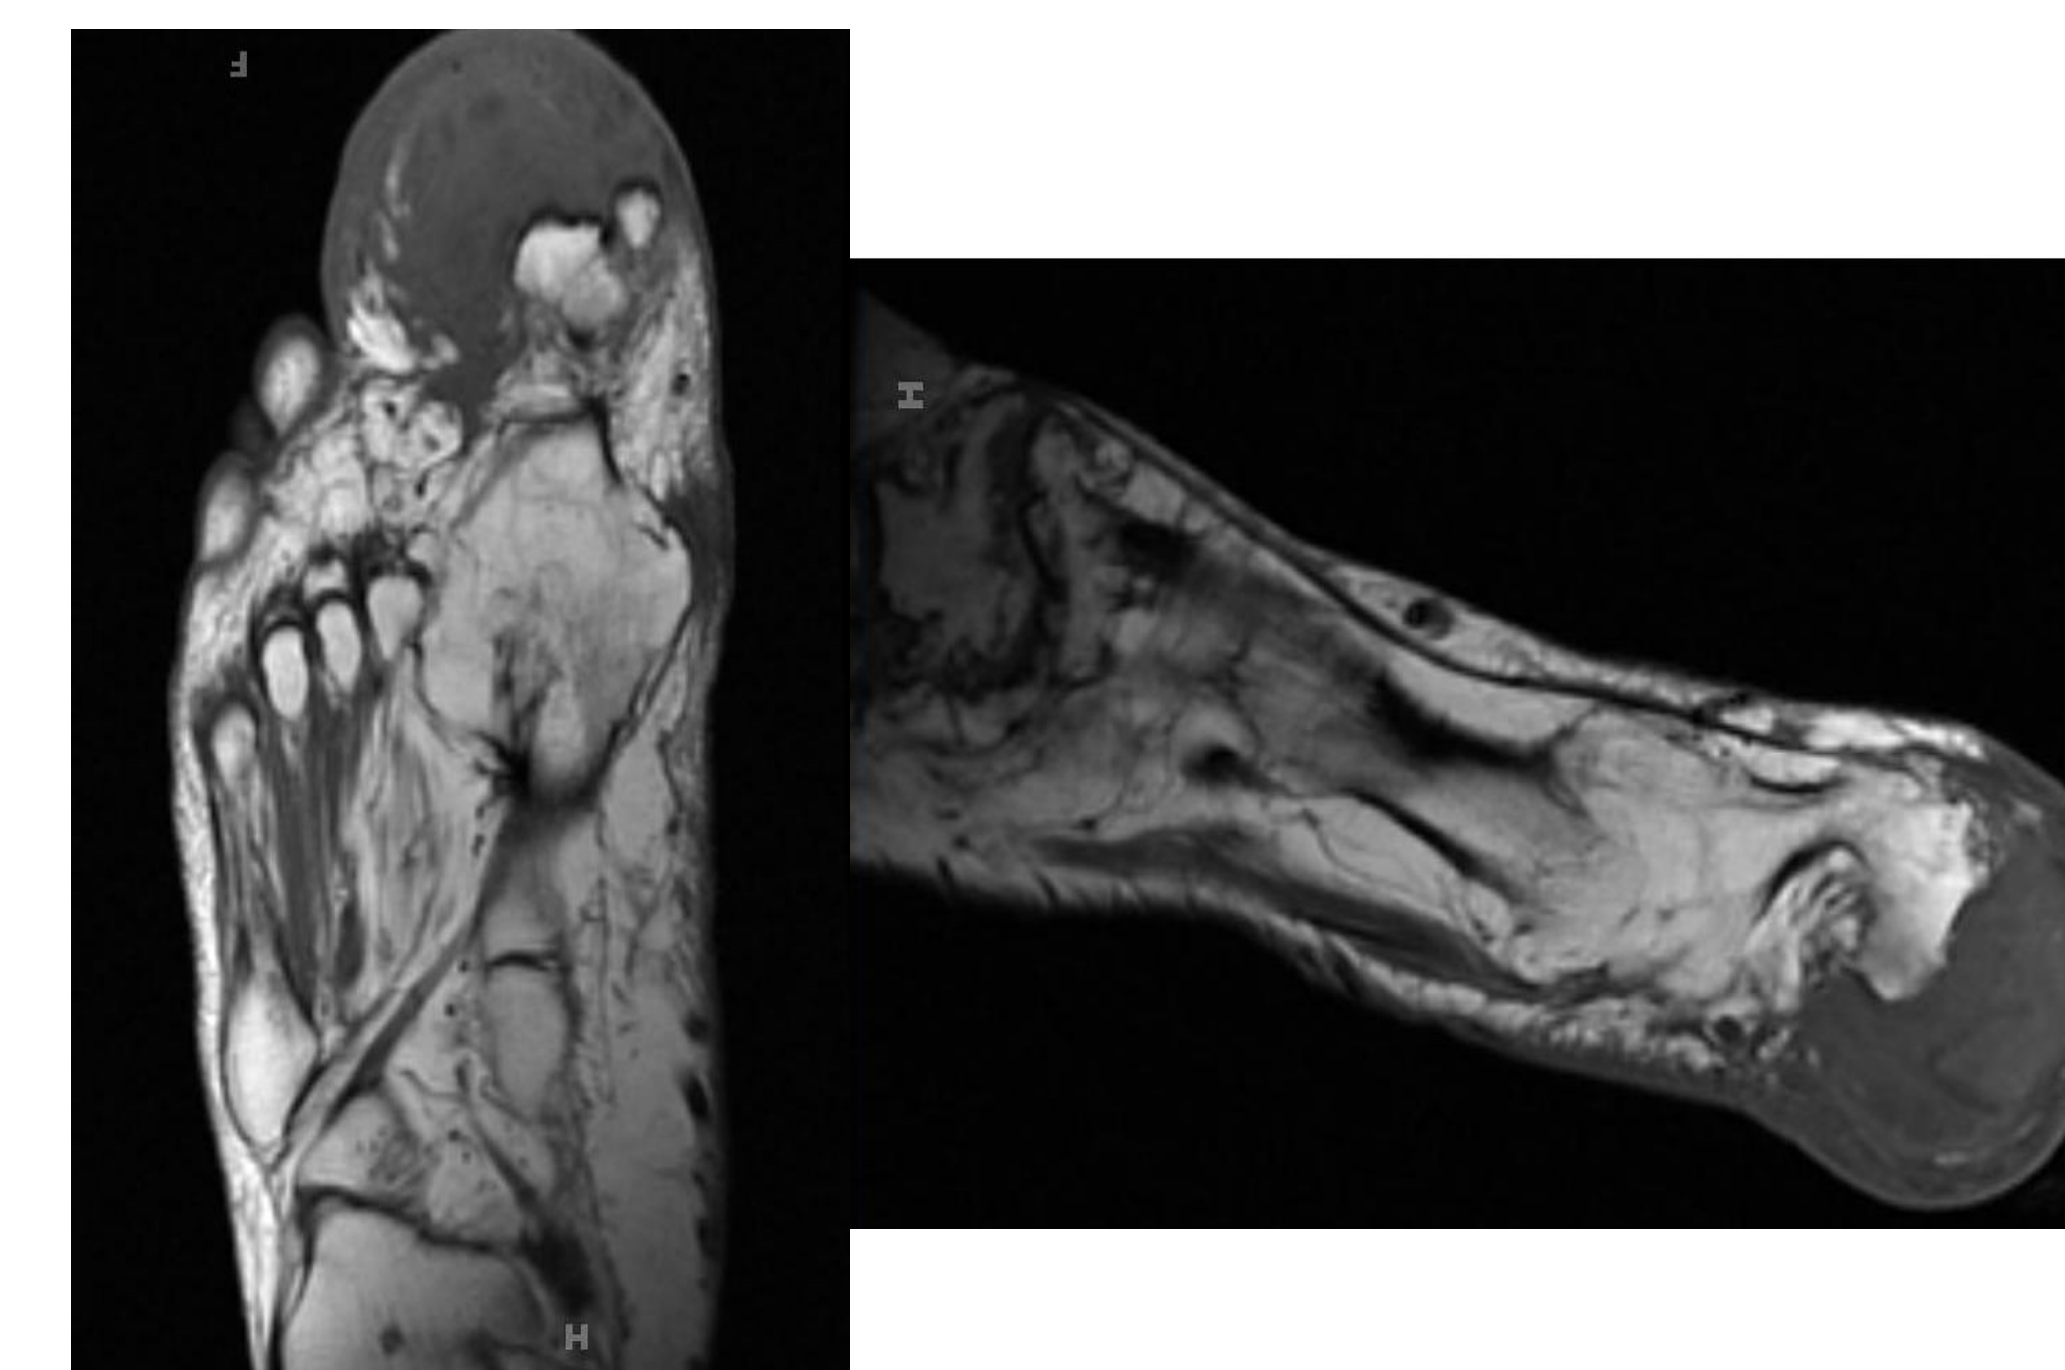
Advanced magnetic resonance imaging; showing no bony or soft tissue infectious processes
